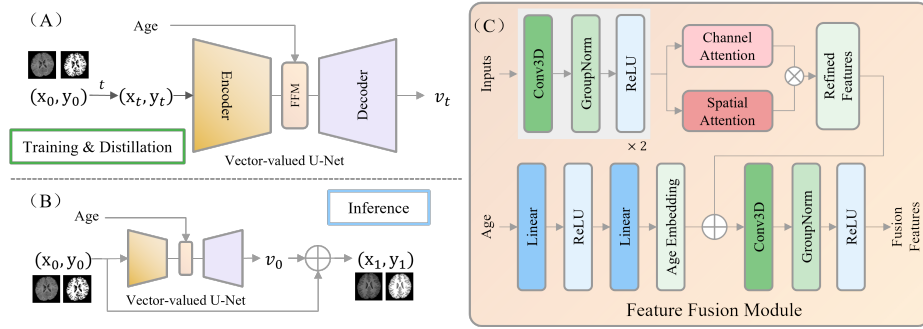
The overall framework of FDRF. (A) During training, the vector-valued U-Net is optimized with $t \sim \mathcal{U}[0, 1]$, while in Flexible Distillation, $t = 0$ is used to enable one-step sampling; (B) Given the age, 6-month-old brain MRI, and tissue labels, the framework samples 12-month or 24-month-old brain MRI and tissue labels; (C) The feature fusion module (FFM) integrates age features and structural features.
